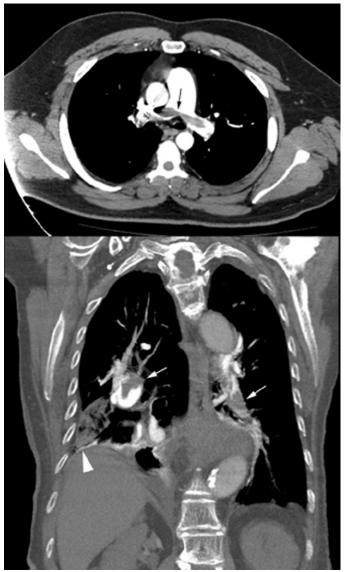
Pulmonary Embolism (PE) Diagnosed by Computed Tomography Angiography. Axial (at the level of the pulmonary artery bifurcation, upper panel) and coronal cuts (just anterior to the thoracic spine, lower panel) showing the presence of PE involving the right and left pulmonary arteries, also known as saddle embolism *(arrows)*. On the coronal cut, there is a wedge-shaped area in the right lower lobe that represents lung infarction *(arrowhead)*.
